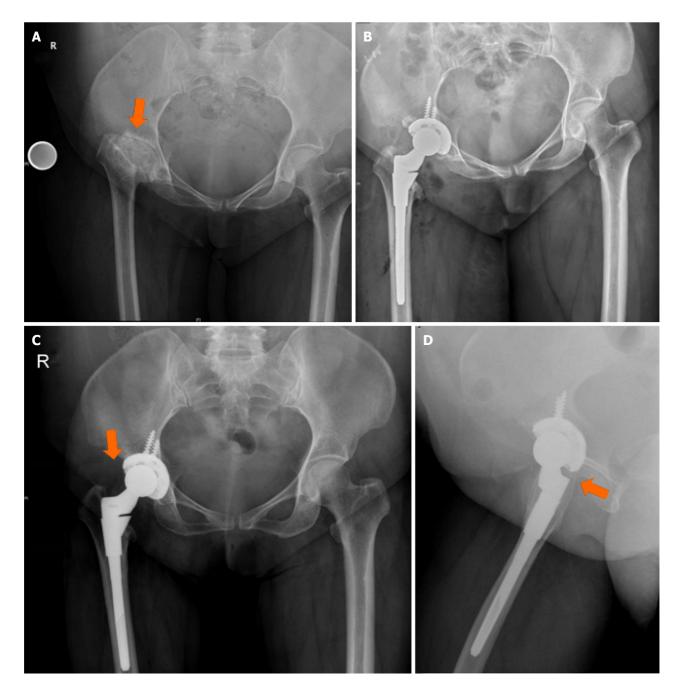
X-ray both hips in a young adult with history of right lower limb shortening and limp since childhood. A: Dysplastic hip sequelae with supratrochanteric shortening and proximal migration; B: Modular stem for neck length and version adjustment; C and D: Follow-up shows restoration of hip centre, offset and length. Arrows show the distortion, offset and the femoral version.
